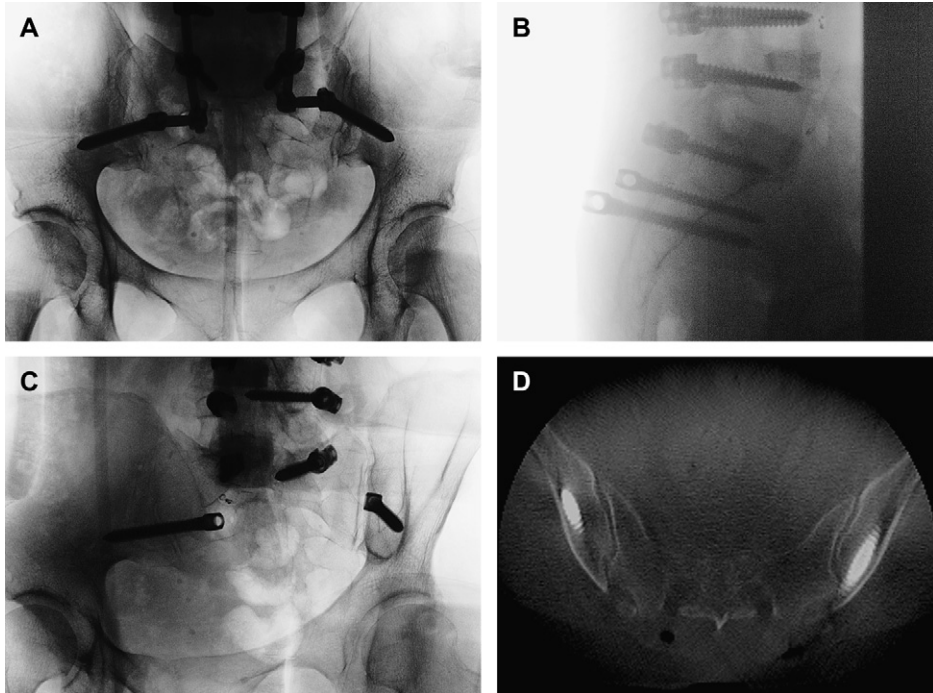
Radiographic Appearance of Iliac Screws. (A, B) Intraoperative AP and Lateral views of the pelvis with iliac fixation at the base of the construct. (C) Left iliac oblique view of the pelvis demonstrating the right screw in the teardrop of the ilium. (D) CT scan demonstrating screws within the iliac crest.
